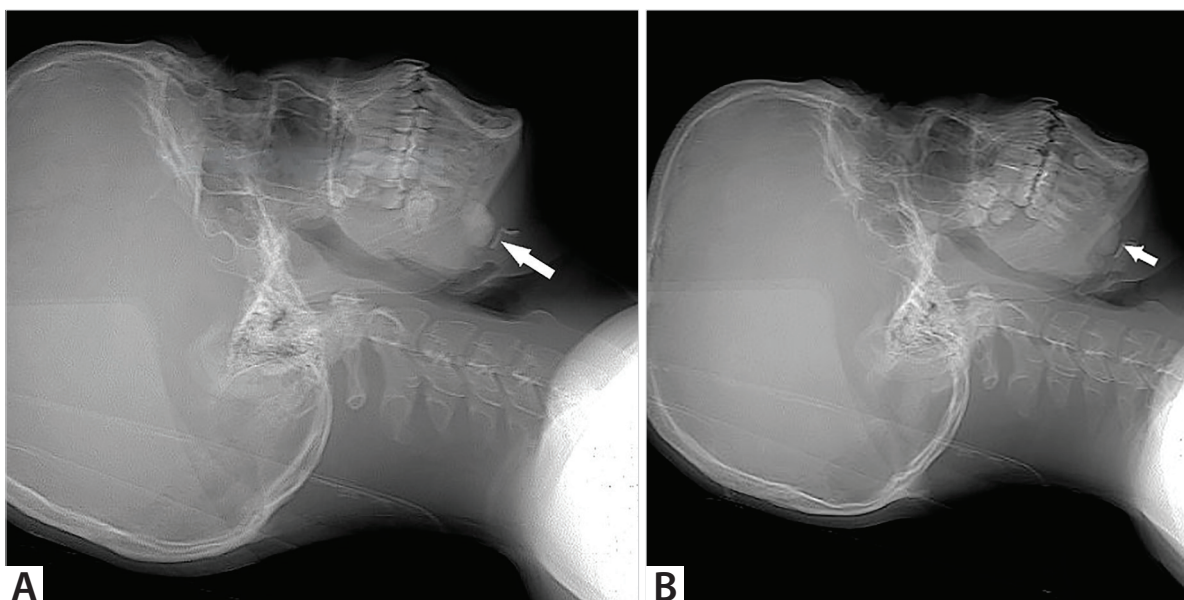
A. In the early phase of Maxillofacial CT of case 1, mandibular osteoma B. In the early phase of Maxillofacial CT of case 2, mandibular osteoma.
